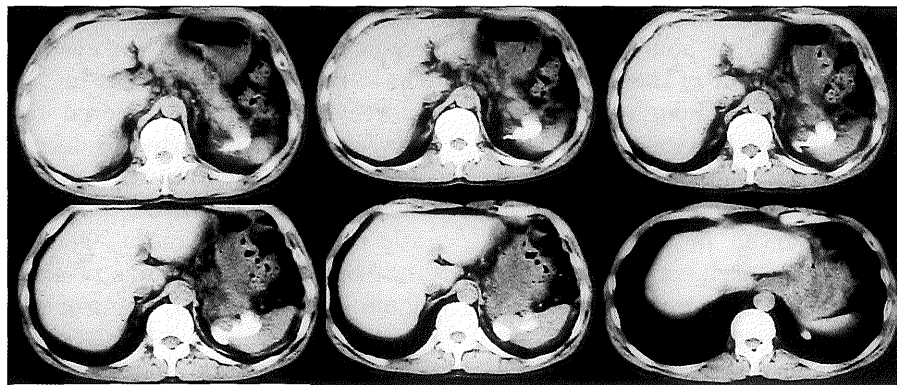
Chest CT on admission showing left lung. There was no apparent tumor in the left thorax.
